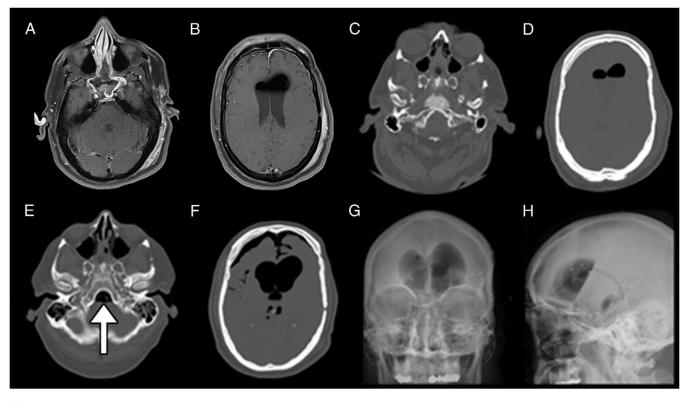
Postoperative pneumocephalus after bilevel positive airway pressure (BiPAP) use. A. and B. Axial cuts of T1 magnetic resonance imaging (MRI) of the head on postoperative (POD)1 showing normal postoperative pneumocephalus and fluid collection in the lateral ventricles. C. and D. Axial cuts of a computed tomographic (CT) scan of the head on POD 4 showing an interval decrease in pneumocephalus after receiving BiPAP, compared with postoperative MRI. E. and F. Axial cuts of a CT scan of the head after receiving BiPAP again on POD 9 with placement of a lumbar drain earlier the same day, with expanded pneumocephalus at the skull base (arrow in E.) and in the lateral ventricles and anteriorly in F. G. Plain anteroposterior and H. lateral views of radiographic films of the head showing a large amount of pneumocephalus with a large air-fluid interface.
